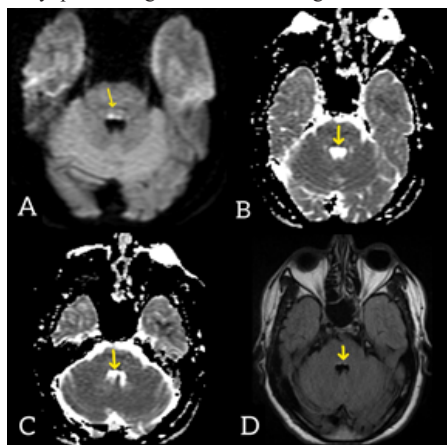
(A)- Axial sections of diffusion weighted imaging showing tiny focal areas of increased signal intensity in the dorsal pons (yellow arrows), (B and C) - Corresponding signal drop in the axial sections of T2-weighted images.
